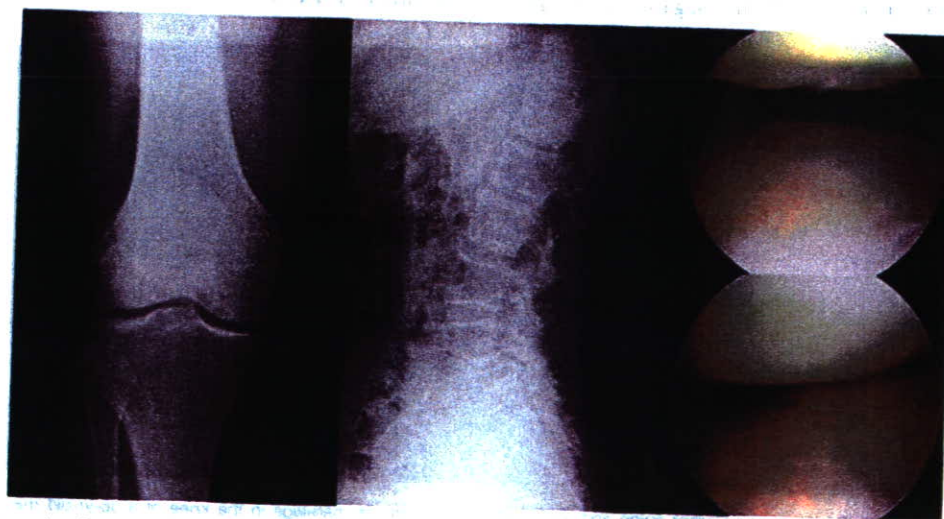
Representative radiographs of the knee and lumbar spine and photograph of the articular cartilage in the knee of a 66-year-old woman with KL grade 0 OA. The SFA score and serum KS concentration were 1.7 and 2145 ng/ml, respectively. The serum KS concentration was high, although the patient had early-stage OA.
